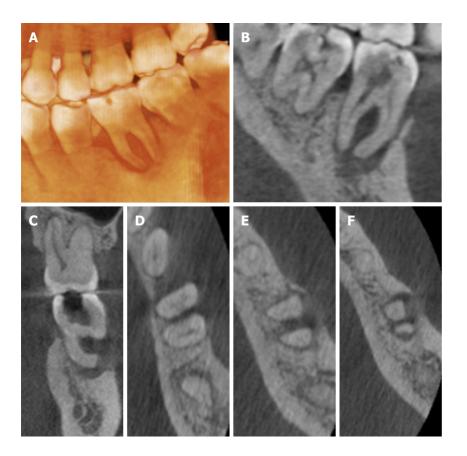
Images of cone beam computed tomography showing buccal, bifurcation, and apical bone resorption (A-F).
